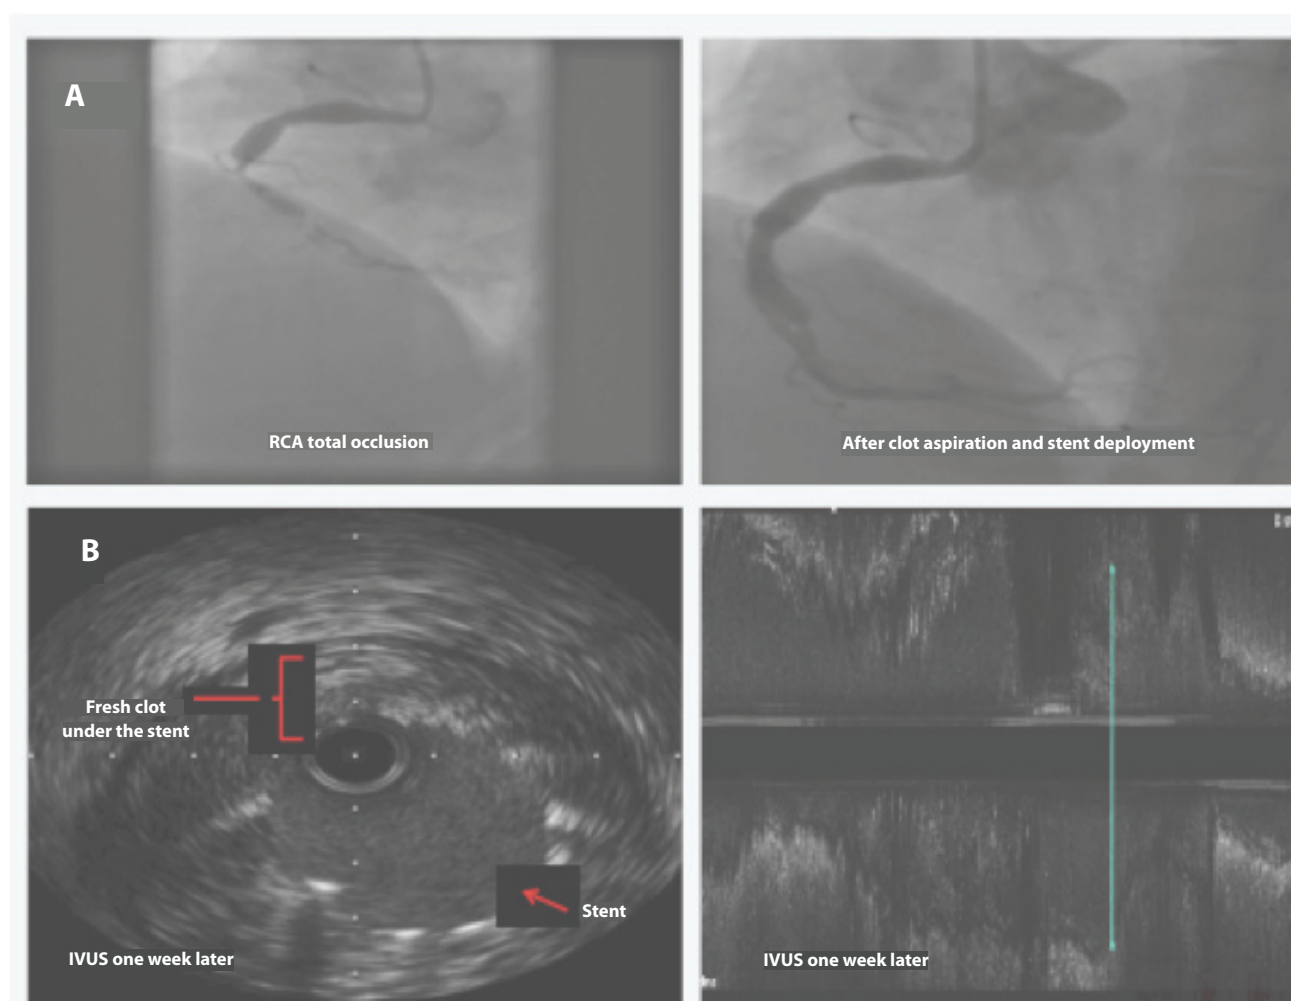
A) Coronary Angiography revealing subtotal RCA occlusion pre and post intervention. B) Intravascular Ultrasound (IVUS) of the RCA one week after PCI showing thrombus underneath stent struts.
